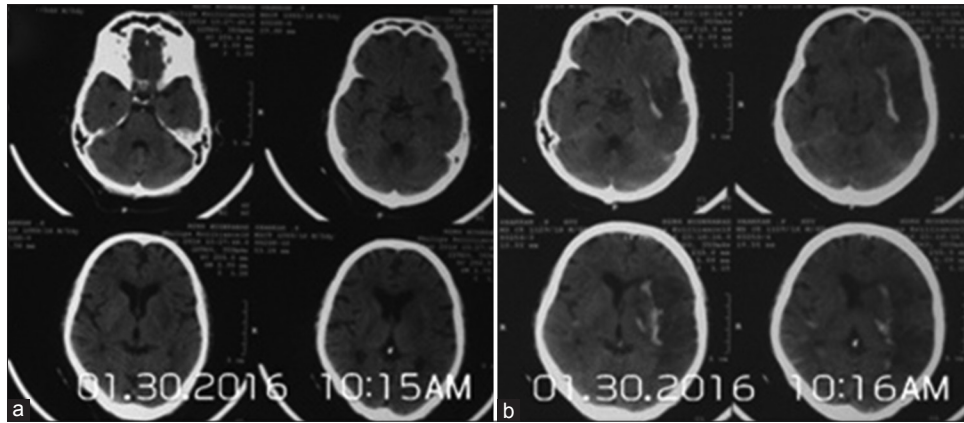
Computed tomography scan brain of 63-year-old patient showing left middle cerebral artery territory infarct (a) with postthrombolysis hemorrhage in subarachnoid space (b)
